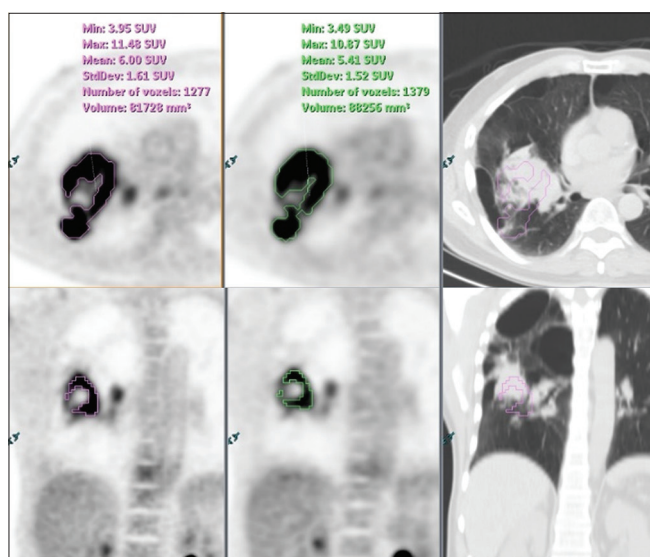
A 68-year-old man with a history of right lung small cell carcinoma for staging. Axial and coronal A-positron emission tomography images (left) showed a volume of 88,256 mm<sup>3</sup> at 35% standard uptake value threshold and D-positron emission tomography images (middle) showed a volume of 81,728 mm<sup>3</sup> for the right middle lobe primary, representing a -7.4% volume reduction at D-positron emission tomography; corresponding computed tomography images (right). Standard uptake value gradient was 3.8 at A-positron emission tomography and 4.0 at D-positron emission tomography, corresponding to a 5.0% increase in sharpness at D-positron emission tomography
